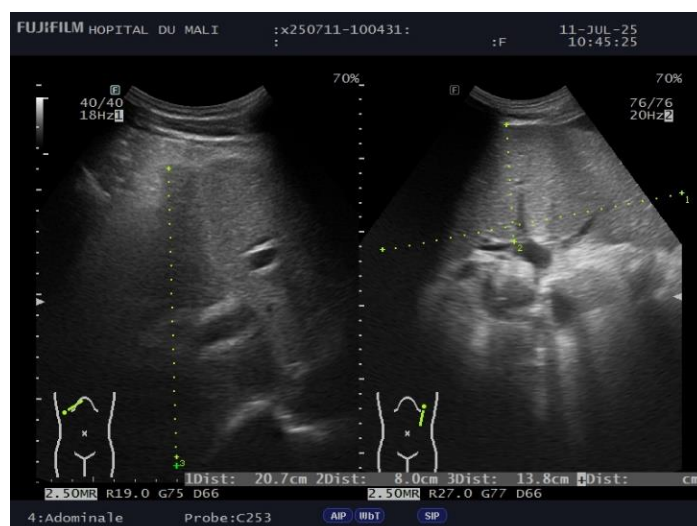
Coronal ultrasound of the liver showing a mottled liver with moderate ascites.
